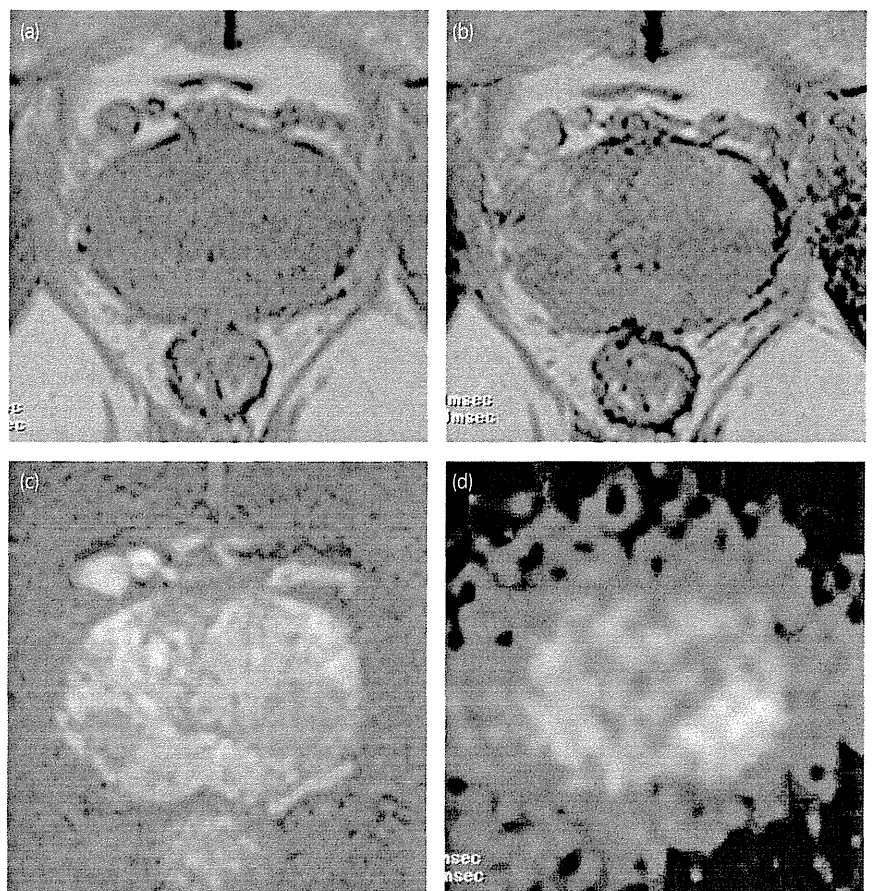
Representative data of a prostate cancer patient shows the pathological ECE cancer in the peripheral zone of the left lobe and the capsular contact cancer in the peripheral zone of the right lobe. (a) There is no residual intraprostatic bleeding caused by biopsy on T1WI MRI. (b) T2WI MRI and (c) T2WI MRI with fat suppression show the ECE cancer focus in the left lobe and the capsular contact cancer focus in the right lobe. (d) DWI MRI shows a positive cancer focus on both sides.
